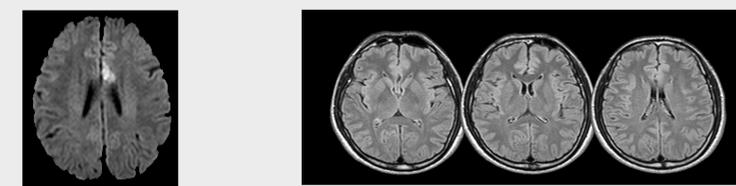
FLAIR image of a 73 year old patient with executive dysfunction (z = -3.71), Right Frontal-insular infarction (12.75 mL or 0.97% of TIV), substantial WMH (10.00mL or 0.76 % of TIV) and mild atrophy (NABPF=0.76). MMSE = 15 and 7 years of education. K- VCIHS Global Score Average of 10 tests Z-Score = -2.69. K- VCIHS Global Score Average of 4 Domains Z-Score = -2.81.
